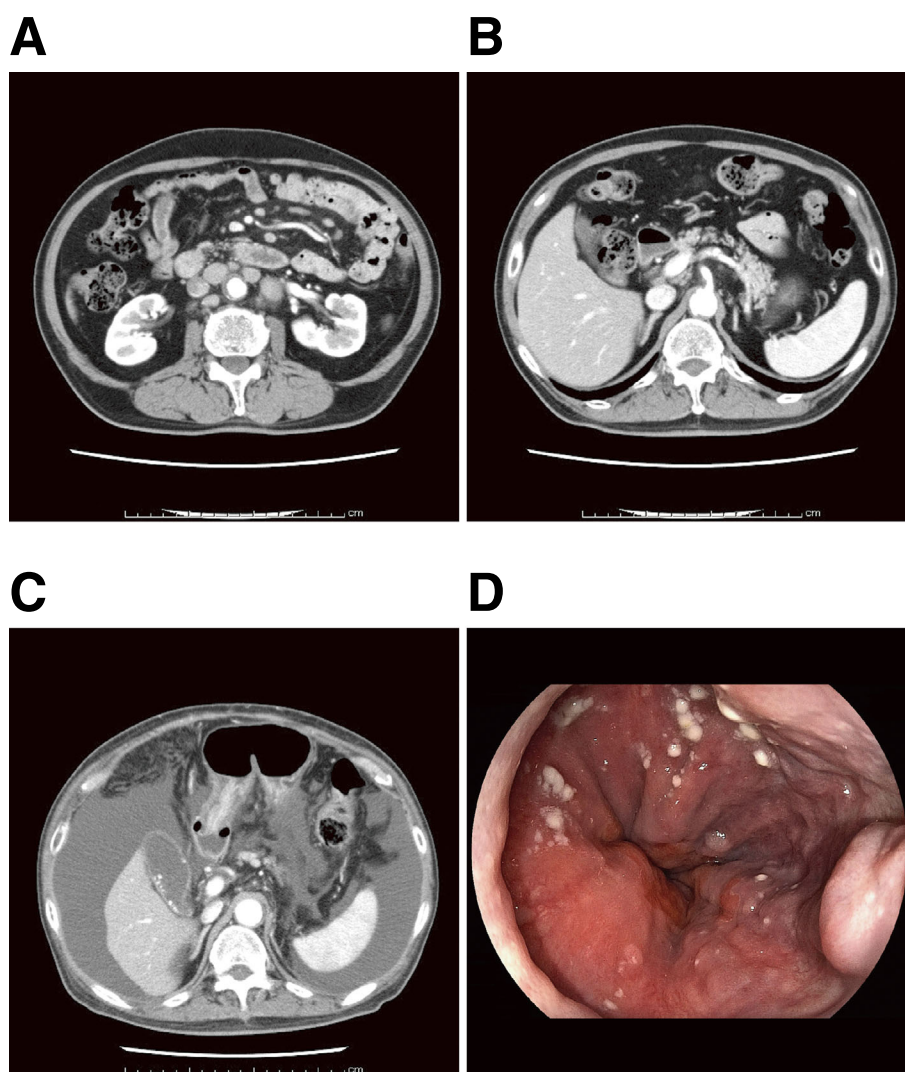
Imaging tests performed before (A, B) and after (C, D) R-CHOP therapy. (A) Our patient presented with systemic lymphadenopathy, including swollen abdominal paraaortic and mesenteric lymph nodes as shown by computed tomography (CT), before R-CHOP therapy. (B) CT showed no abnormal morphological results in the liver or spleen before R-CHOP therapy. (C) Massive ascites and atrophy of the liver were revealed by CT 10 months after the commencement of R-CHOP therapy. (D) Oesophageal varices were observed using oesophagogastroduodenoscopy 11 months after the treatment.
